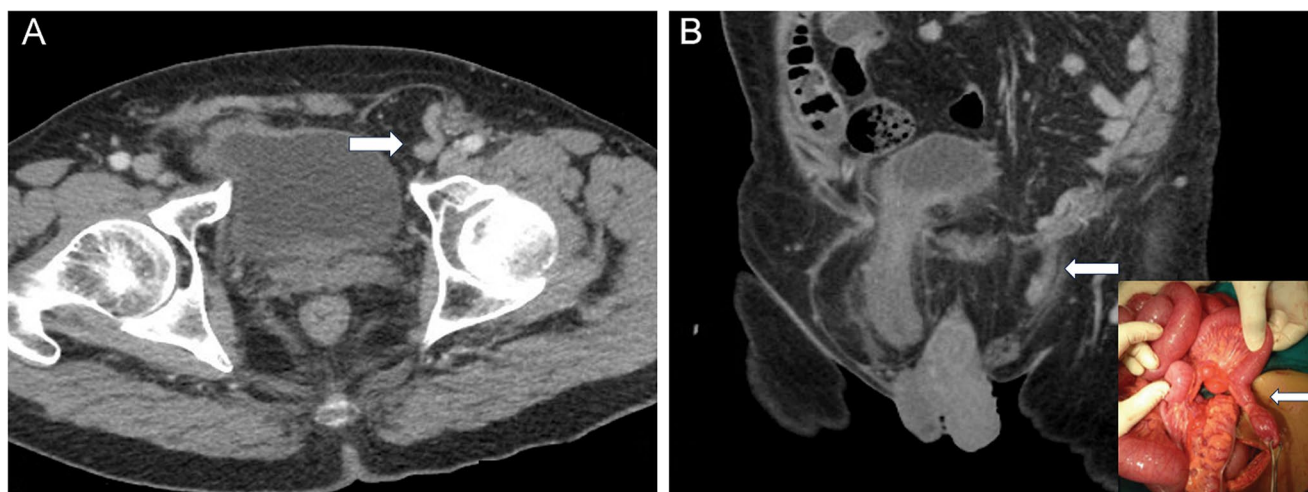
A, B Axial and coronal CT images of the abdomen and pelvis in a 68-year-old man demonstrate a Meckel's diverticulum protruding into the left inguinal hernia (arrows) while the bladder has herniated on
